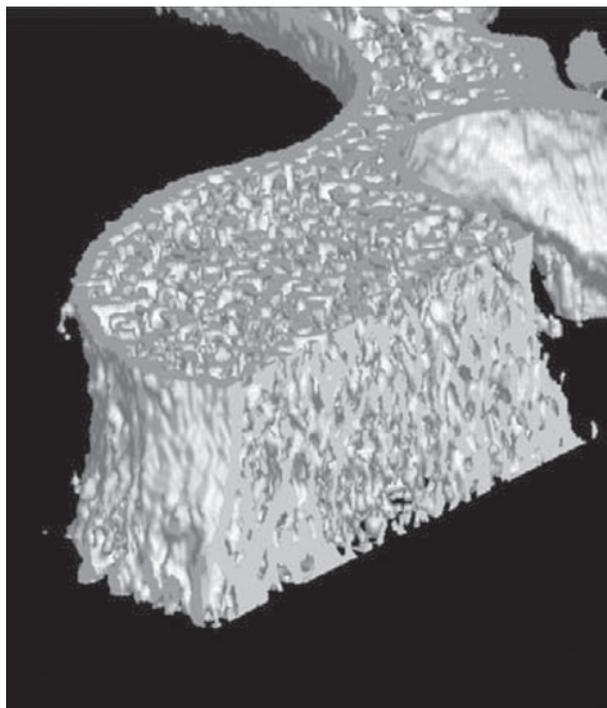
High-resolution *in vivo* CT image of the spine. The 3D rendering reveals the connectedness of the trabecular network but also reveals that stereological parameters cannot be determined accurately. Courtesy of Masako Ito.
